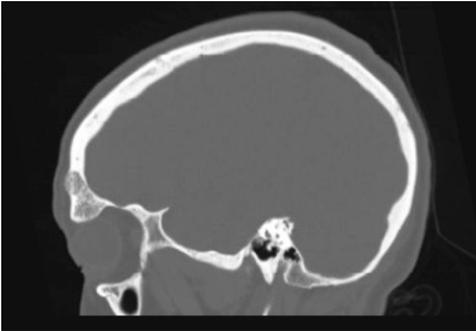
Sagittal computed tomogram showing intraosseous hemangioma.
